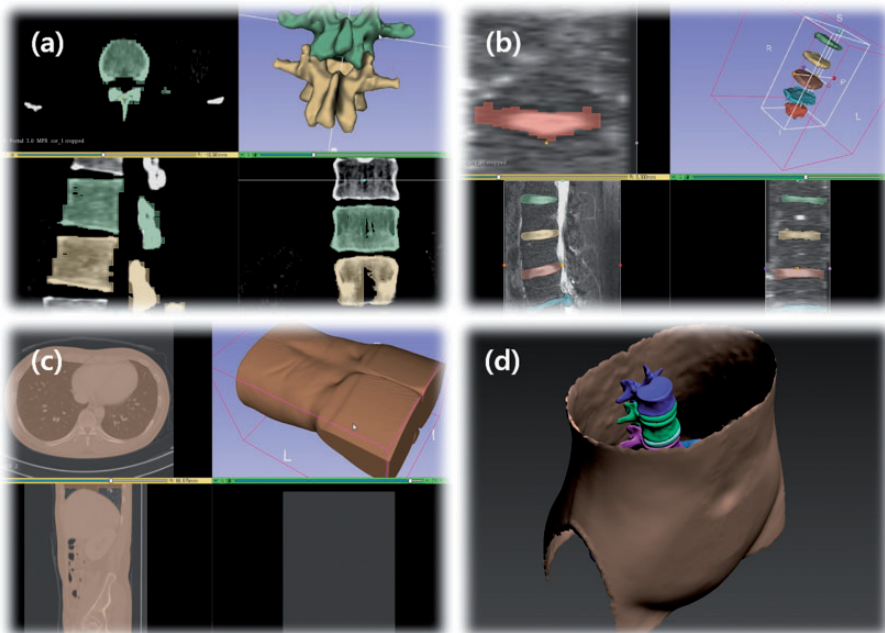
Segmentation of the vertebrae and pelvic bone, intervertebral discs, and body contour using the 3D Slicer software package applied to computed tomography (CT) and magnetic resonance imaging data. (a) Vertebrae and pelvic bone from CT. (b) Intervertebral discs from magnetic resonance imaging. (c) Body contour from CT. (d) Combined surface mesh data.
